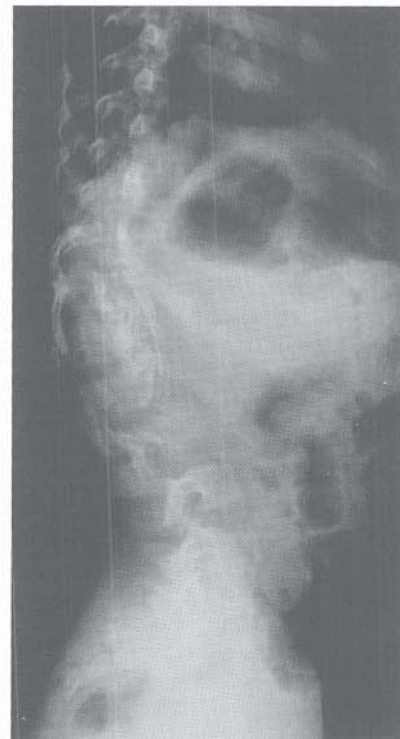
A, Lateral radiograph of a 1+9-year-old girl with achondroplasia. Note the beaklike irregularities of the anterior vertebral bodies at the thoracolumbar junction. B, The child was treated with a TLSO orthosis.
